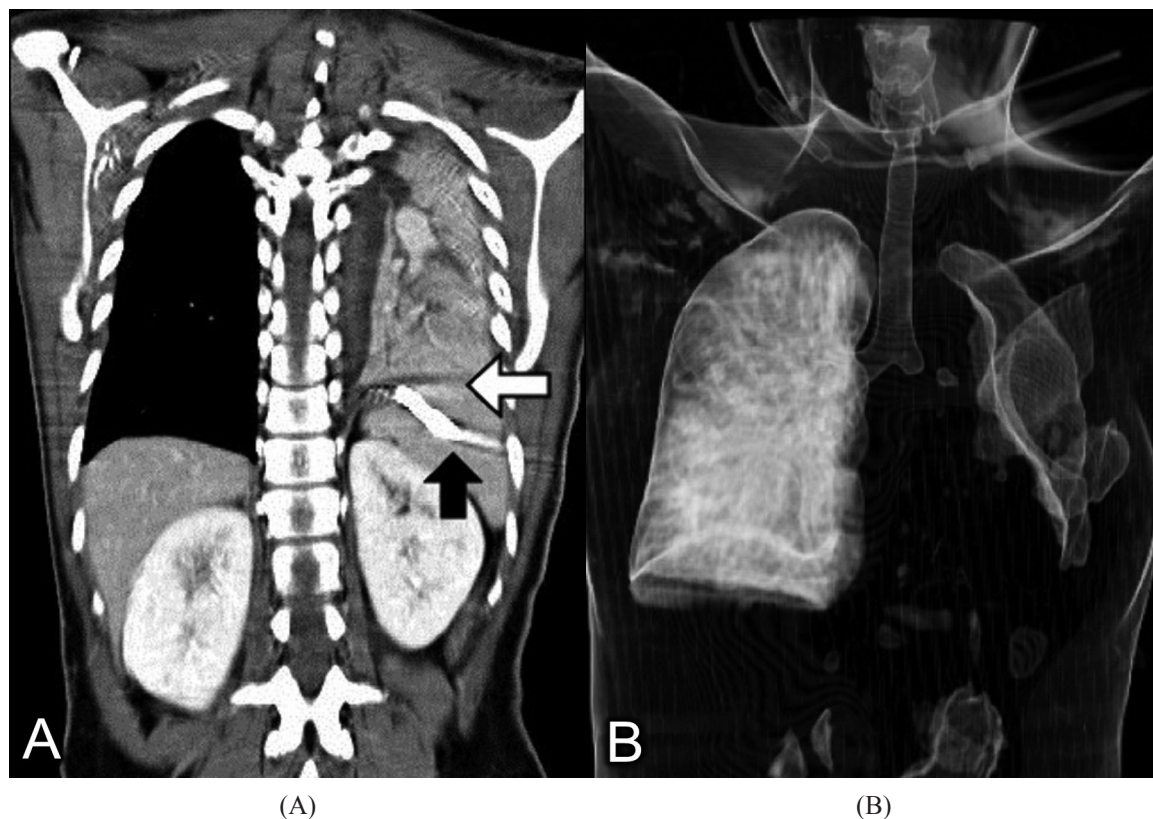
A. CT scan coronal view revealed the elevated hemidiaphragm (white arrow) due to collapsed lung and the spleen penetrated by the pigtail (black arrow). B. Overt left main bronchus obstruction on CT image reconstruction.
